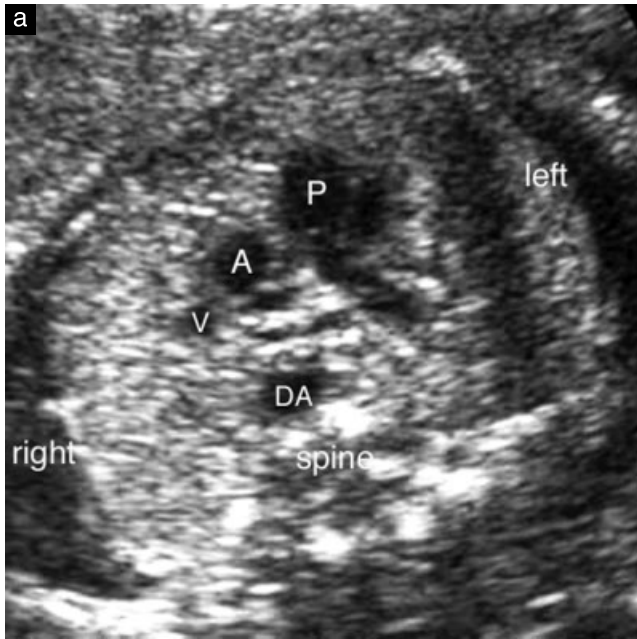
Double aortic arch with left-sided ductus. (a) Three-vessel view shows the descending aorta (DA) slightly displaced to the right. (b) Transverse sonogram of the aortic arch shows that the two aortic arches (R and L) completely encircle the trachea (T). The left ductus arteriosus connects the pulmonary artery (P) to the left aortic arch. The aortic arches, ductus and pulmonary artery together form a figure of '9'. A, ascending (ventral) aorta; V, superior vena cava.
